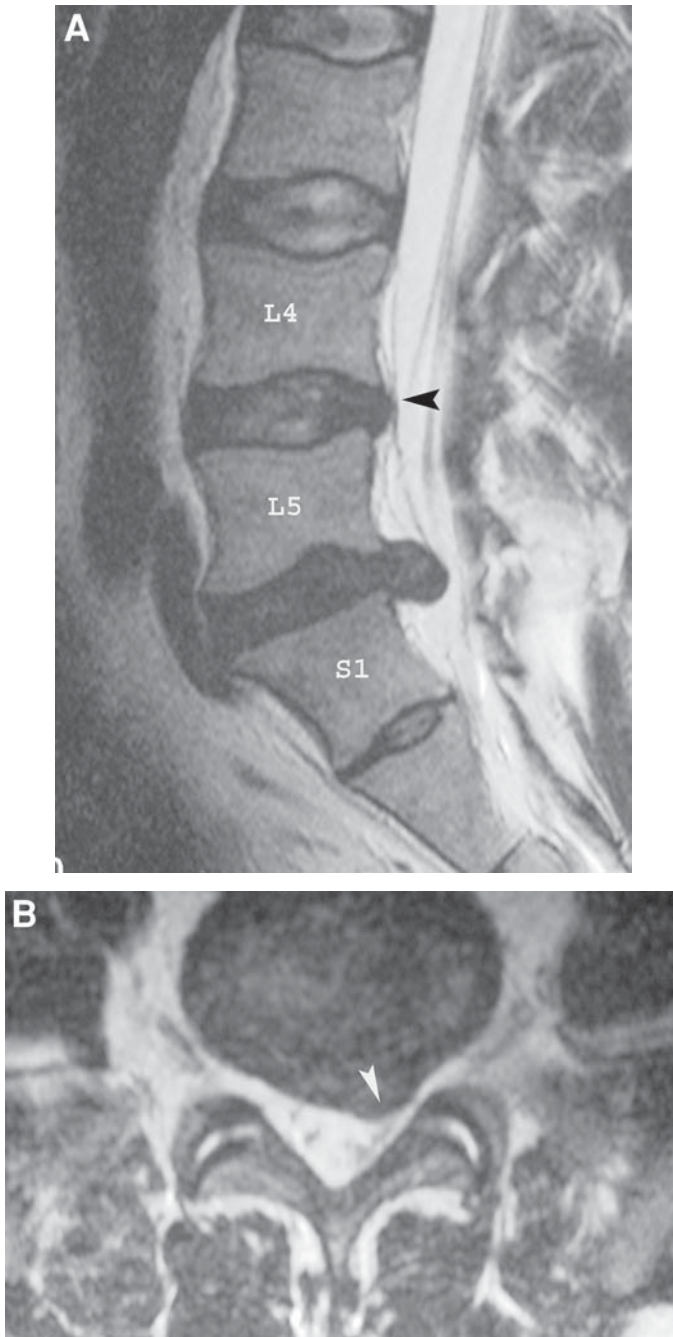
(A) Sagittal T2-weighted MRI of the lumbar spine showing a large disc herniation at L5–S1. This would not be amenable to percutaneous techniques. Also notice the disc bulge at L4–5 (*arrowhead*). This could be treated with IDET or nucleoplasty if indicated. (B) Axial T2-weighted MRI at L5–S1. The *arrowhead* demonstrates the large disc herniation.
